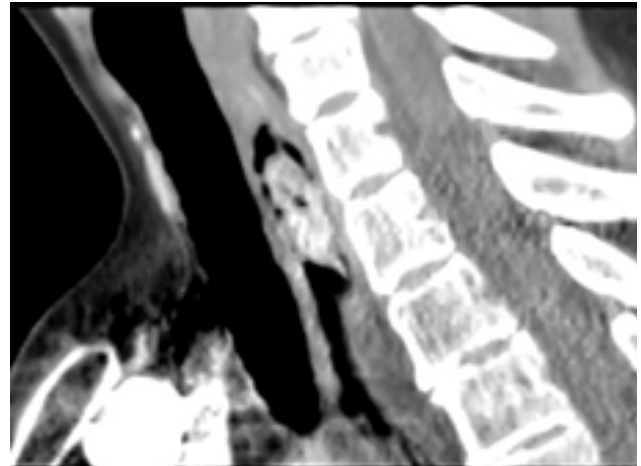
CT image of the esophageal polyp.
